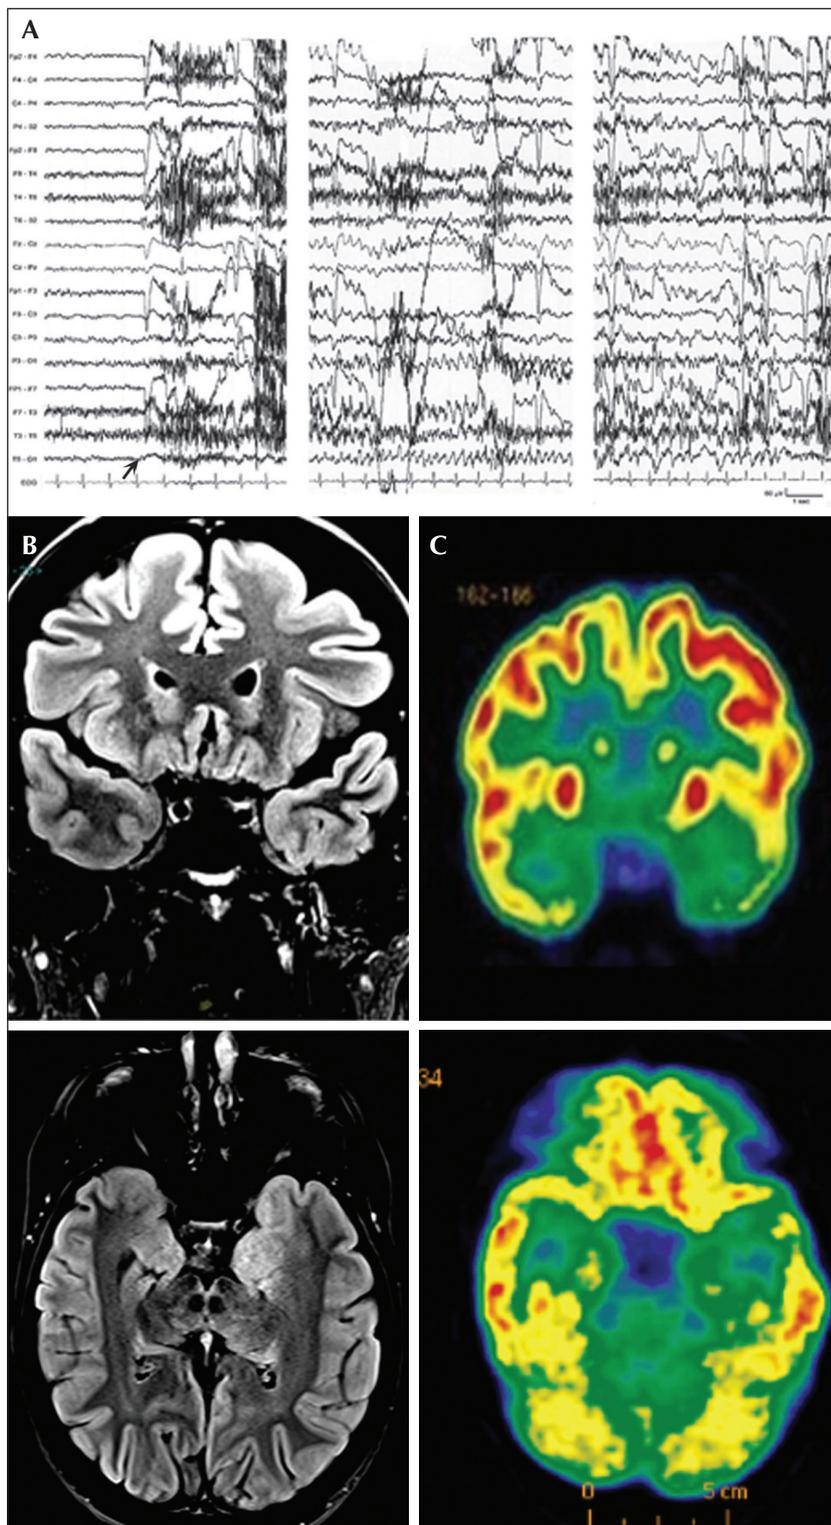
Case 1. (A) EEG recording of a typical seizure clinically characterized by sudden auditory aura and fear followed by loss of contact. The EEG shows a 4-Hz rhythmic theta activity involving the left temporal regions with posterior predominance. The seizure onset is indicated by the arrow. (B) 3T MRI (T2 TSE DARK FLUID sequence) showing mild left temporal hypotrophy, slight blurring of the white and grey matter in the left temporal lobe and hyperintensity of the left hippocampus on coronal (upper panel) and axial (lower panel) planes. (C) FDG-PET showing left temporal (polar and mesial) hypometabolism on coronal (upper panel) and axial (lower panel) planes.
